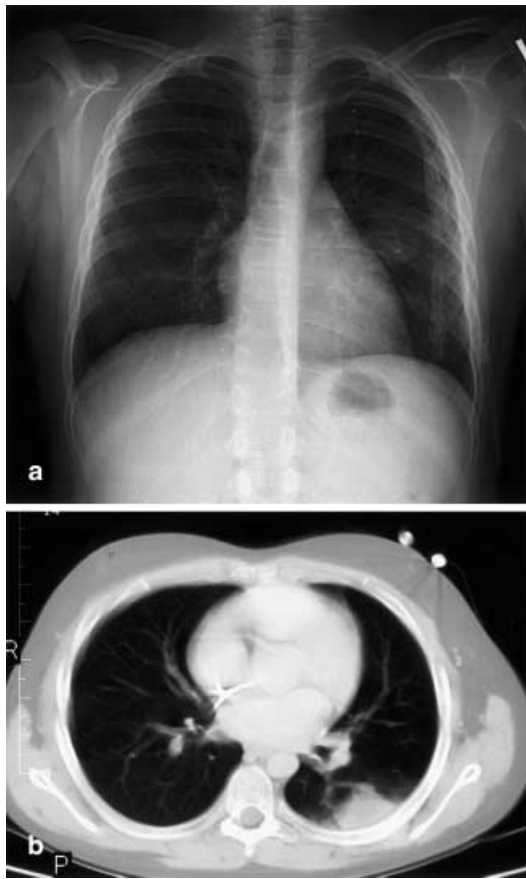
a Posterior-anterior chest radiograph showing a round density in the left lower lobe. b Computerized tomography (CT) scans of the chest and abdomen demonstrating a pleural based density measuring 3.5×2 cm in the left lower lung with a necrotic center
